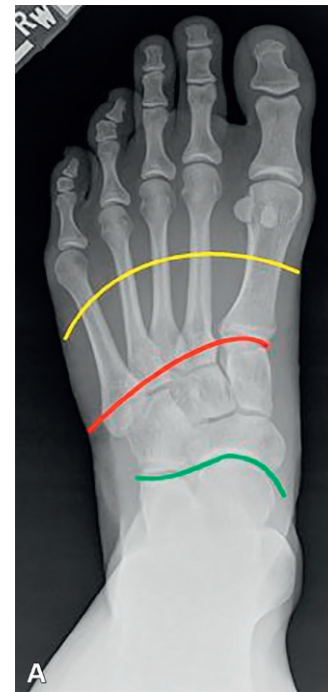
Anterior-posterior (A) and lateral (B) radiograph of the foot with the transection levels for transmetatarsal (yellow), Lisfranc or tarsometatarsal (red), and Chopart or midtarsal (green) amputations.
